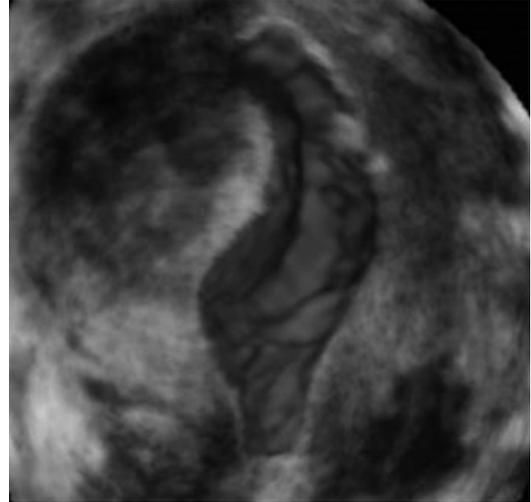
3D image of saline infusion sonography (SIS) in uterus with submucous fibroid
